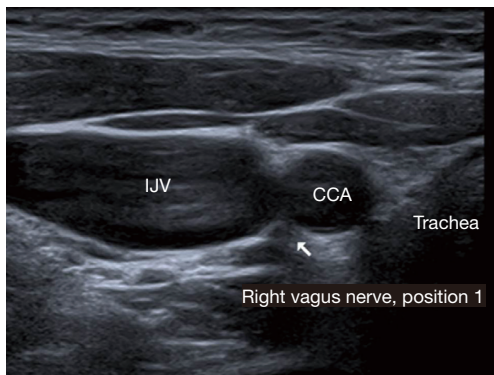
Ultrasound aspect of the right vagus nerve (white arrow) in position 1. THYR, thyroid lobe; IJV, internal jugular vein; CCA, common carotid artery.
